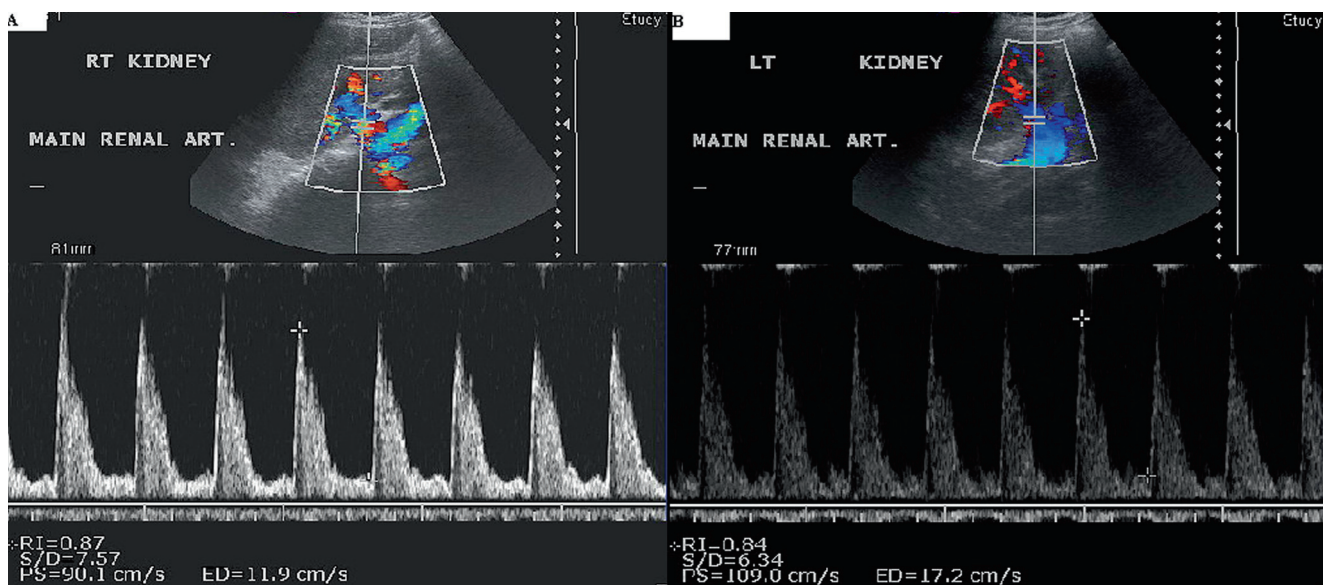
Color Doppler ultrasound. (a) RI of the right kidney 0.87 (suggestive of obstruction). (b) RI of the left kidney 0.84 (suggestive of obstruction)
